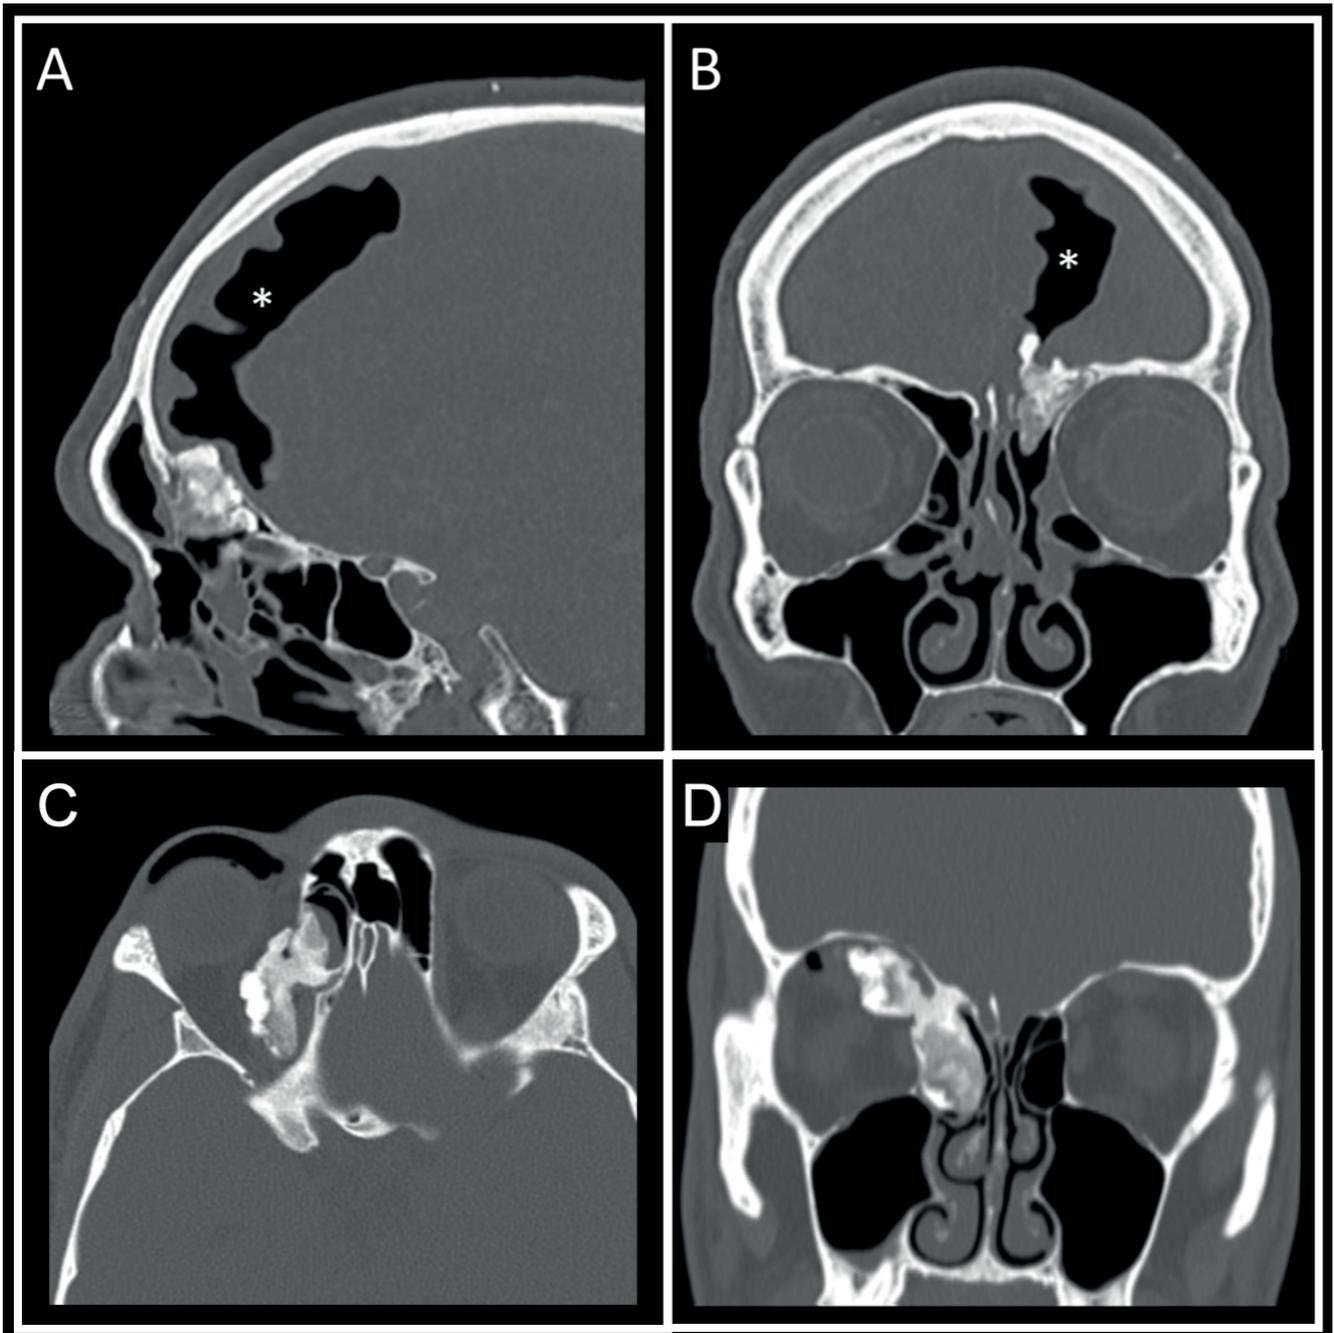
A, B) Preoperative CT-scan images (A coronal, B sagittal) showing a case of osteoma with intracranial extension complicated with spontaneous pneumocephalus due to valve mechanism (white asterisk). C, D) Orbital emphysema due to valve mechanism of an osteoma with intraorbital extension (C axial, D coronal) (pictorial case not included in the analysis).
